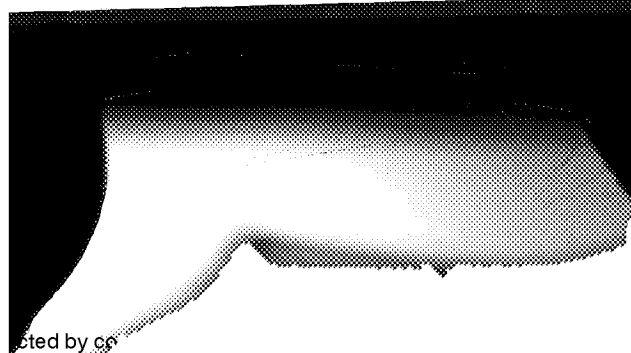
Myeloma (plasmacytoma) of the sternum is demonstrated in this x-ray film.
